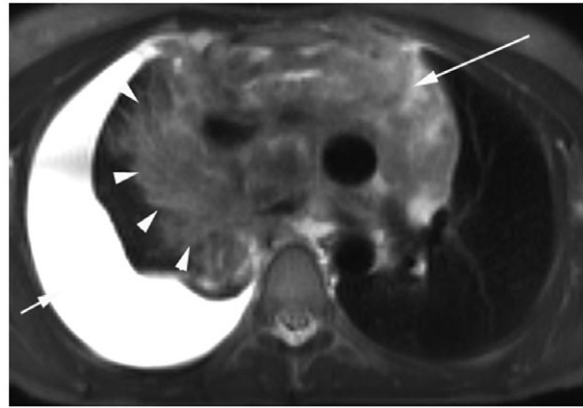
Axial short time inversion recovery (STIR) MRI (TR 5.97, TE 60, TI 130 ms) of a patient with HL, showing a large mediastinal mass (long arrow), with direct lung infiltration (arrow heads) and a large pleural effusion (short arrow).
